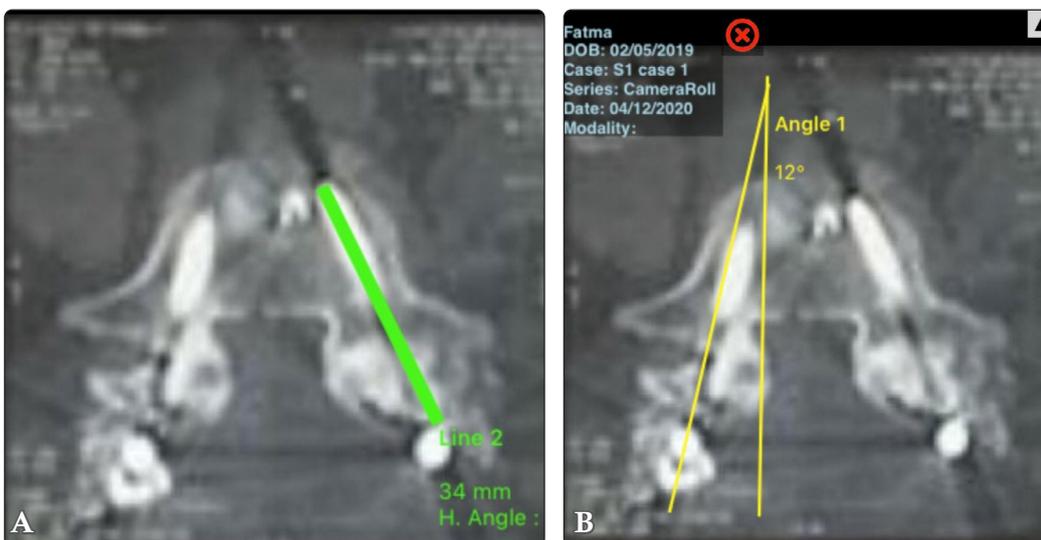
(A) Axial cut of CT-scan showing the intraosseous length of S1 screw (34mm). (B) Axial angle of S1 screw.
